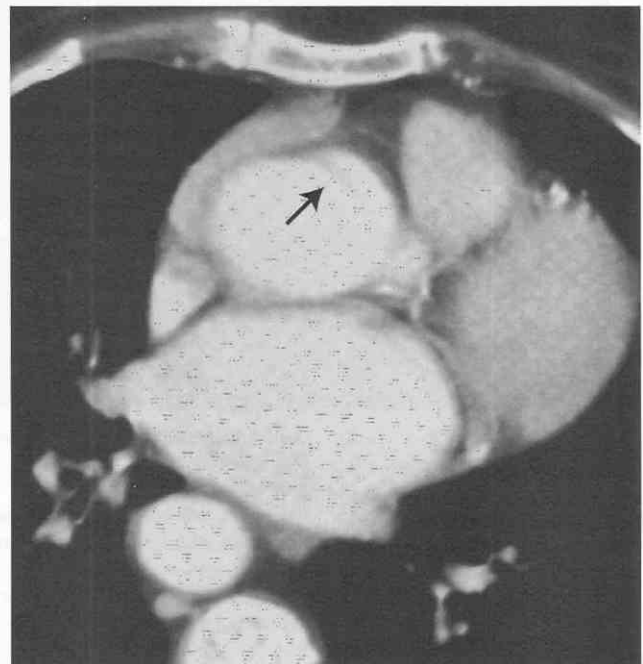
Motion artifact. Contrast-enhanced axial CT image shows apparent intimal flap (arrow) at the level of the aortic root. This appearance is caused by cardiac motion during scan acquisition. It can be recognized by its characteristic location at the aortic root. It is usually found in a left anterior or right posterior location.
